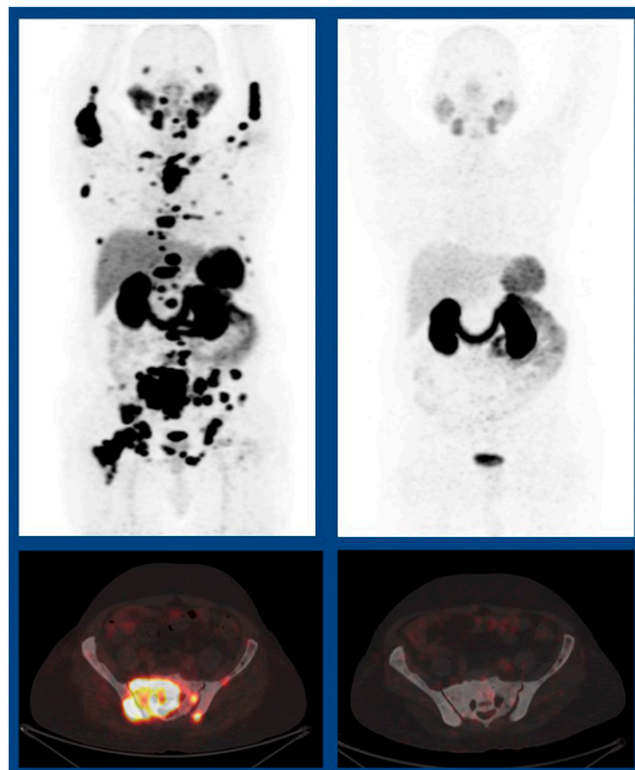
^{225}Ac -PSMA-617 targeted α -therapy in metastatic castration-resistant prostate cancer. Example ^{68}Ga -PSMA-11 PET/CT images from patient at baseline (left; prostate-specific antigen [PSA] = 48.5 ng/mL) and after 4 cycles of ^{225}Ac -PSMA-617 (right; PSA undetectable).
